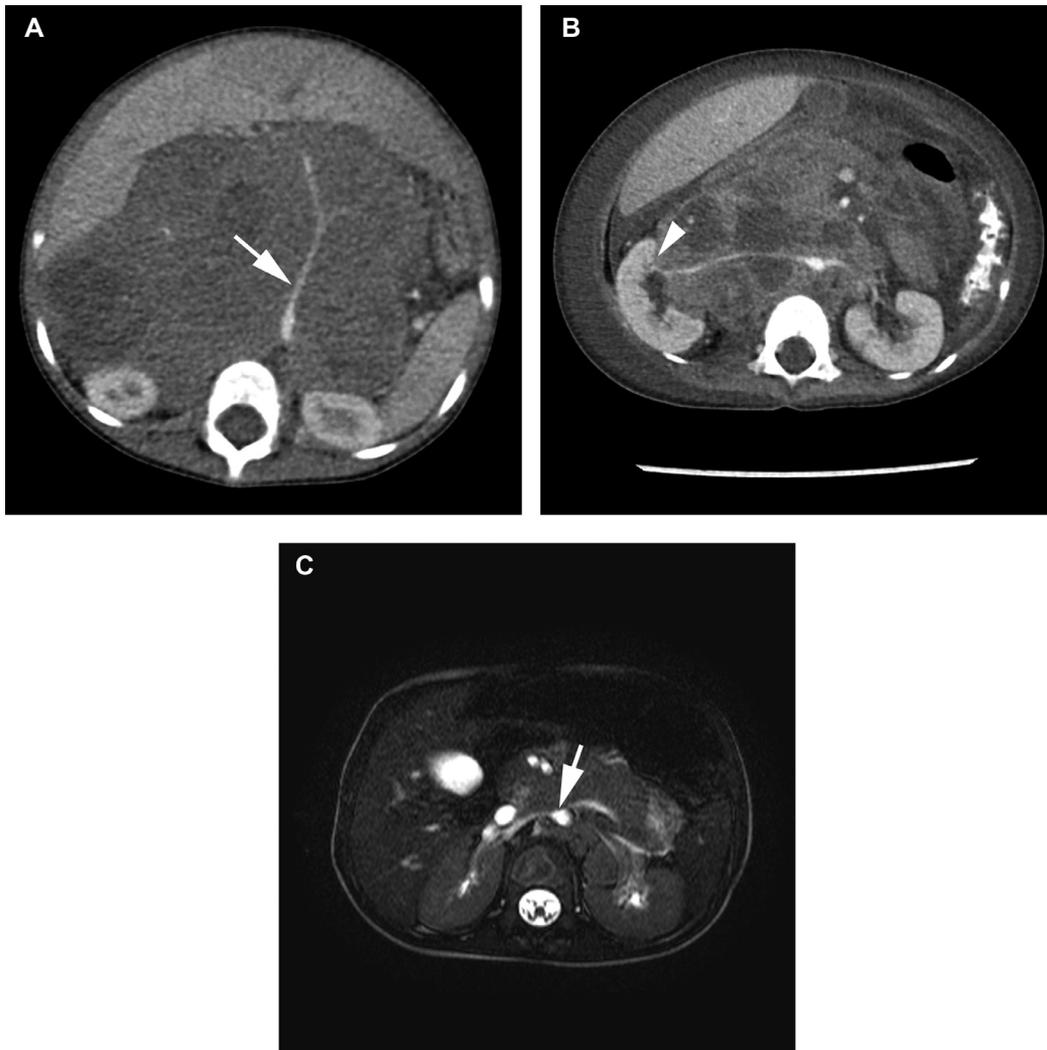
Arterial encasement, consistent with the presence of an IDRf (L2). (A) Contrast-enhanced CT of 1-year-old male with a retroperitoneal solid mass with complete *encasement* of the aorta and celiac axis (arrow). Note there is also *flattening* of the inferior vena cava without a visible lumen (an additional IDRf). (B) Contrast-enhanced CT of 3-year-old boy with a heterogeneous, mainly right retroperitoneal mass, *encasing* both renal arteries and aorta (positive IDRf). Note there is also renal parenchyma *infiltration* on the right side (arrow head) (an additional example of an IDRf) and *flattening* of the inferior vena cava to the extent that it is not visualized (a 3rd example of an IDRf). (C) T2-weighted MR image of 2-year-old boy with a retroperitoneal tumor that *encases* right renal artery and aorta (arrow).
